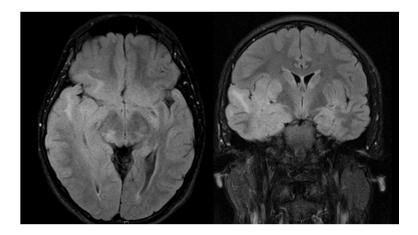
Axial and Coronal FLAIR images showing hyperintense cortical and subcortical signal with edematous right temporal lobe. Involvement extends to left temporal lobe and brainstem.
